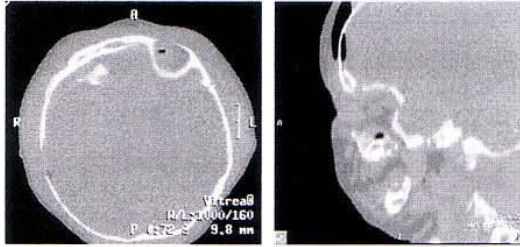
Computed tomography scan 1 month after surgery depicting the bowstring in a horizontal and lateral view.
